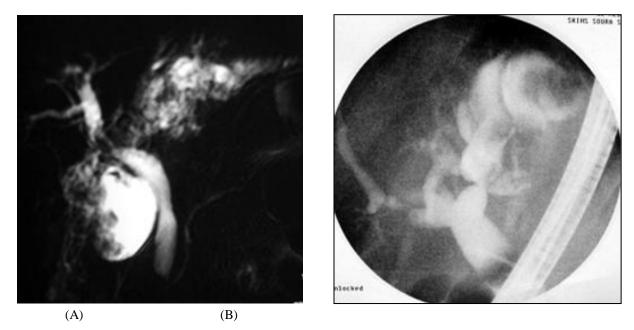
A 30 years old male had 2 episodes of cholangitis with Ultrasound evidence of RPC, she underwent MRCP(A) which shows multiple stones in involving LHD and RHD both segments with multiple stones and strictures. ERCP(B) done revealing stones in CBD, stricture in LHD and RHD. Note at MRCP better visualization of stones and strictures in major hepatic ducts and its' branches
